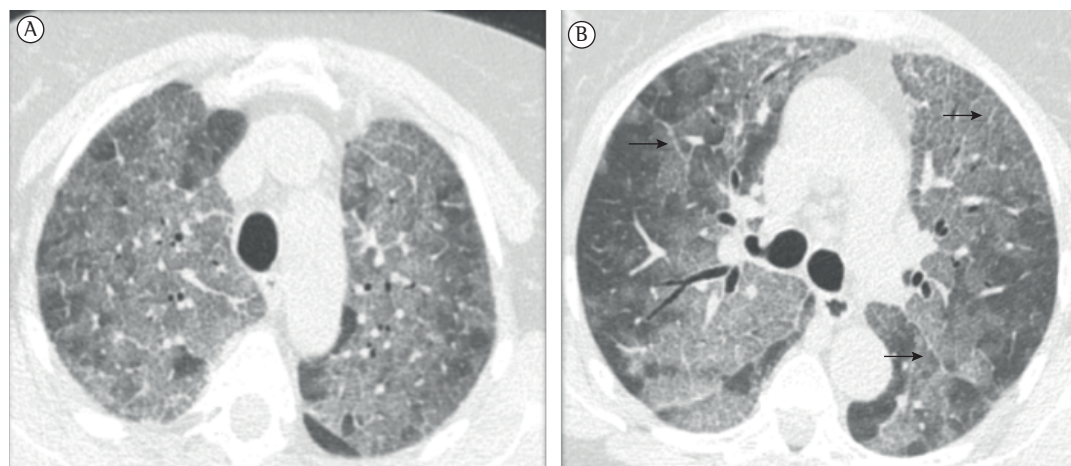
HRCT scan of the chest showing pulmonary ground-glass opacities, predominantly in the upper lobes, in A, and in the central regions, in B, associated with areas of smooth interlobular septal thickening (arrows).
